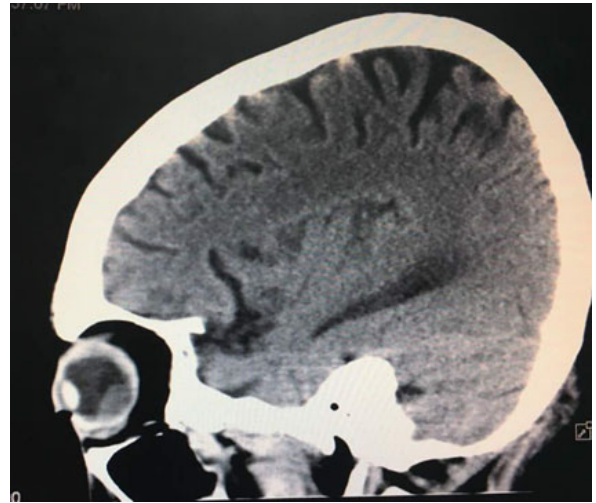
sagittal cross section of CT brain shows choroidal mass in the left eye.
